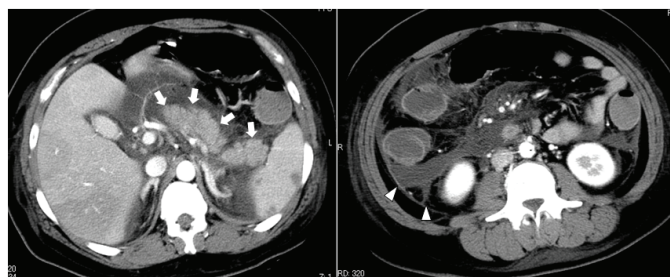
CT imaging of abdomen (Case 2)
